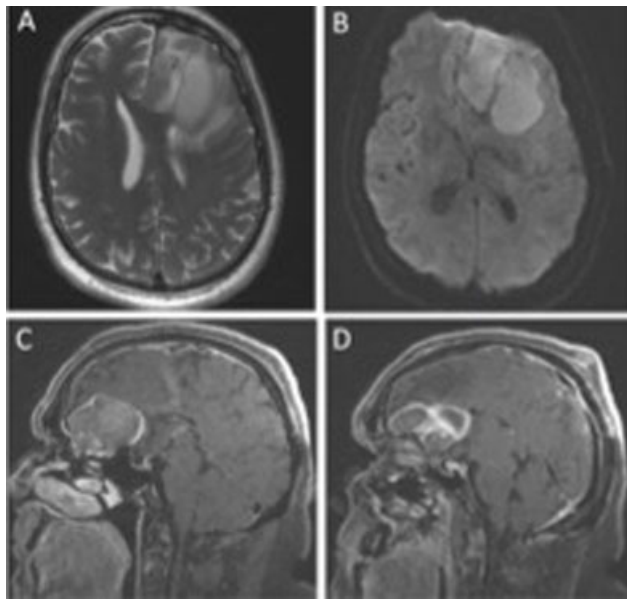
(A) Axial T2 with contrast and (B) DWI MRI revealing a complex bilobed left frontal abscess with 5.6 cm × 3.1 cm × 4.4 cm medial lobe and 5.7 cm × 3.3 cm × 3.5 cm lateral lobe. (C), (D) Sagittal T1 MRI demonstrating mostly intra-axial lateral lobe and medial lobe extending anteriorly in cranial fossa.
